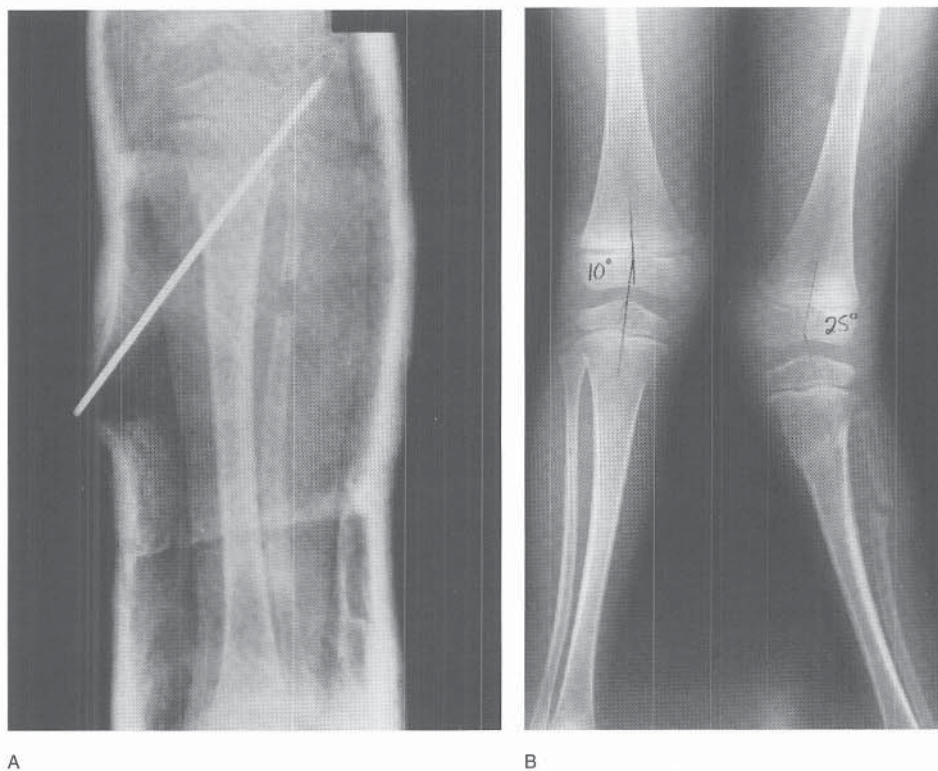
A, At age 4, a left proximal tibial rotation osteotomy was performed to correct excessive unilateral external tibial torsion. B, Radiographic appearance 8 months postoperatively. A significant valgus deformity has resulted.
